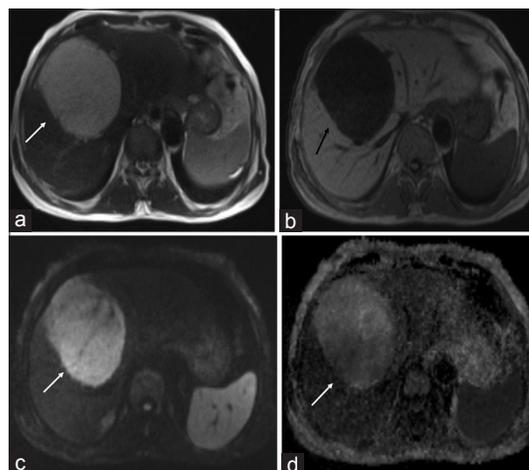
Magnetic resonance images of the same patient as Figure 5. Axial T2-weighted showing large homogeneously hyperintense lesion in the liver (white arrow, a) and homogeneously hypointense on T1 images (black arrow, b). Axial diffusion-weighted magnetic resonance image showing heterogeneously hyperintense signal in the lesion (white arrow, c) and apparent diffusion coefficient map showing hyperintense signal corresponding to the diffusion-weighted imaging (white arrow, d) which signifies no e/o diffusion restriction within the lesion and mean apparent diffusion coefficient value $1.55 \times 10^{-3} \text{ mm}^2/\text{s}$. Later, multiphase contrast-enhanced computed tomography was done which is showing typical features of hemangioma
